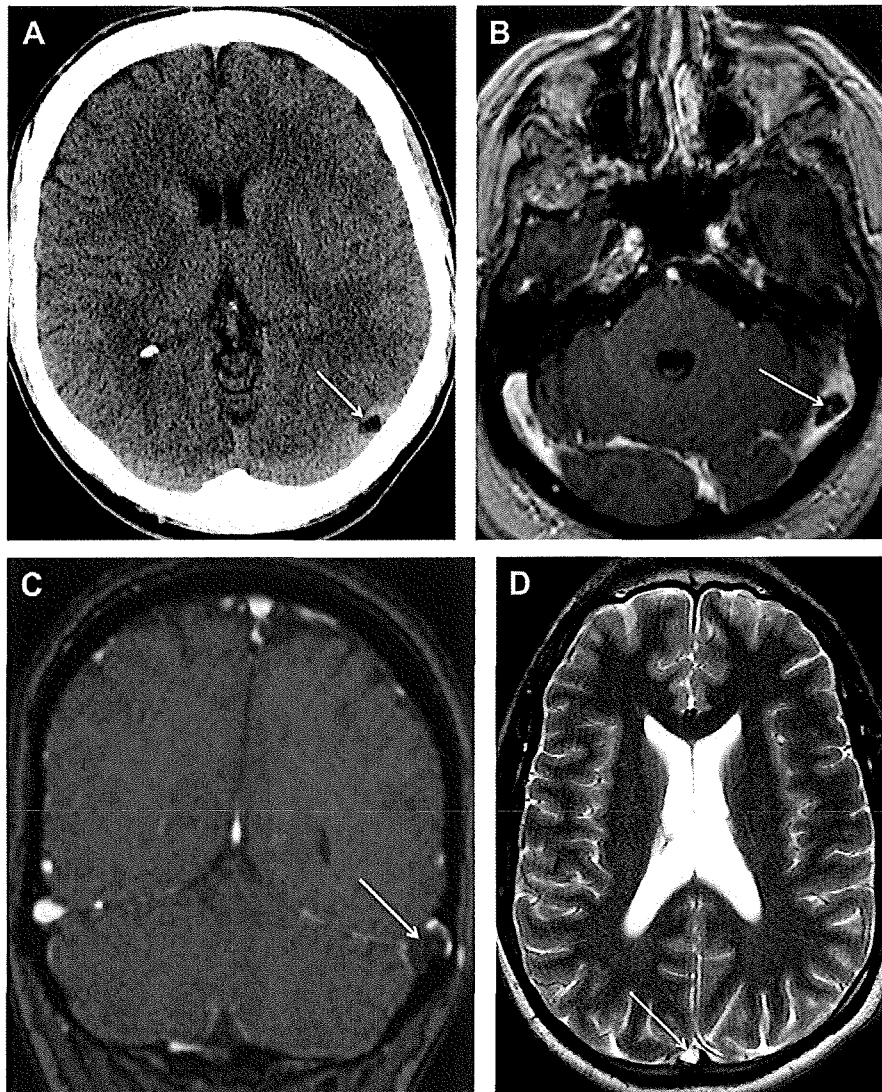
Arachnoid granulations. Noncontrast axial CT image (A) demonstrates a focus of cerebrospinal fluid (CSF) attenuation (*arrow*) within the left transverse sinus consistent with an arachnoid granulation. Axial postgadolinium 3D magnetized-prepared rapid gradient echo (MP-RAGE) image (B) shows a filling defect (*arrow*) in the distal left transverse sinus with a typical location and appearance of an arachnoid granulation. Coronal postgadolinium 3D MP-RAGE image (C) shows an unusually large arachnoid granulation (*arrow*) as a filling defect in the distal left transverse sinus. Axial T2-weighted image (D) depicts a round T2 hyperintense structure (*arrow*) in the superior sagittal sinus demonstrating CSF signal and is compatible with an arachnoid granulation.
